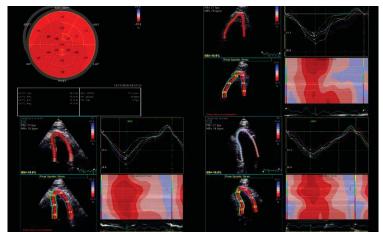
Example of speckle-tracking echocardiography for calculation of longitudinal strain values
